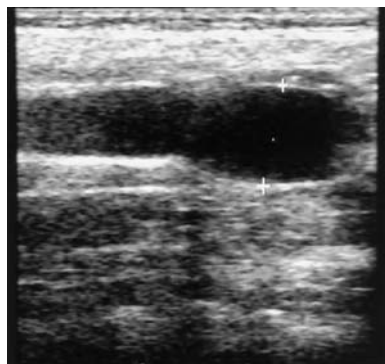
Ultrasonography scan showing an hypoechoic mass, measuring 3 cm \times 10 cm, located deep in the lateral muscle compartment of the right leg.
